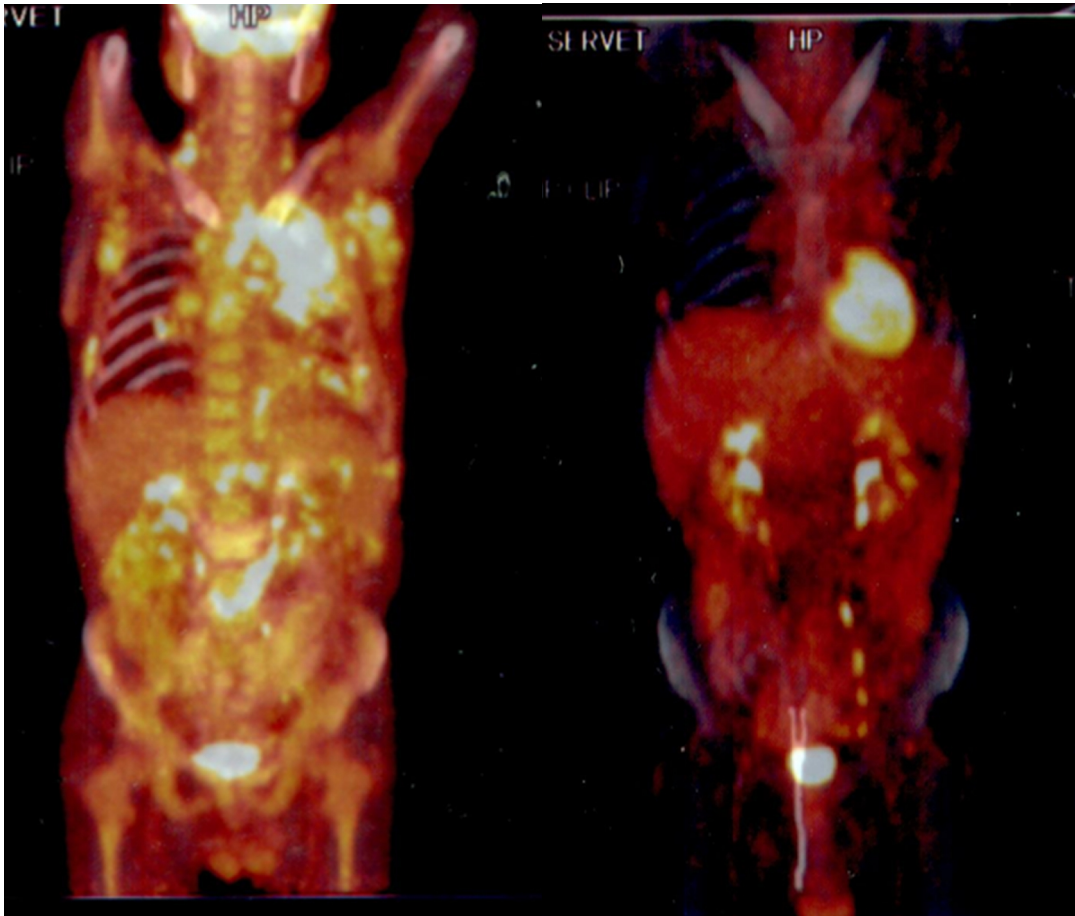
PET CT before and after bendamustine in case 1
